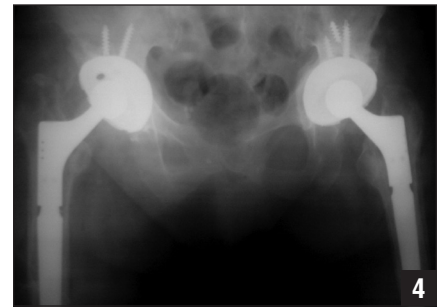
Anteroposterior radiograph of the pelvis demonstrating bilateral component reimplantation following successful infection eradication.
